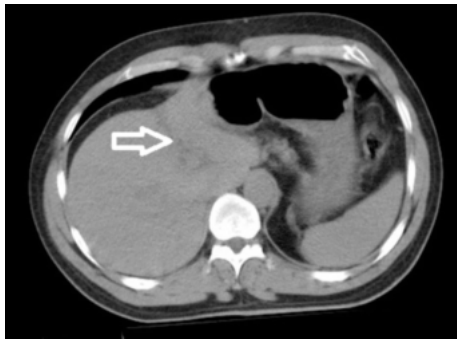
CT image of liver laceration (grade 2 = capsular tear 1-3 cm parenchymal depth, <10 cm in length).
